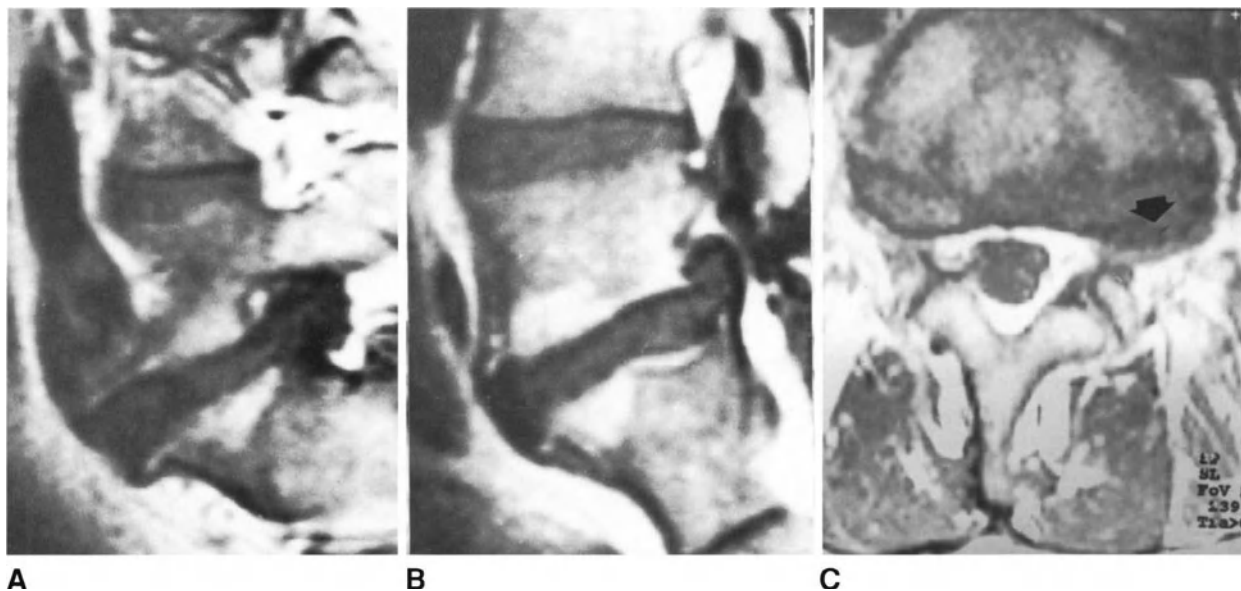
Disc herniation and isthmus spondylolisthesis. (A) and (B) Turbo spin-echo T1-weighted sagittal MR images showing an intraforaminal disc herniation and Grade I spondylolisthesis of L5. (C) Spin-echo T1-weighted axial MR image at L5-S1 level revealing an intraforaminal herniation on the left (arrow).
